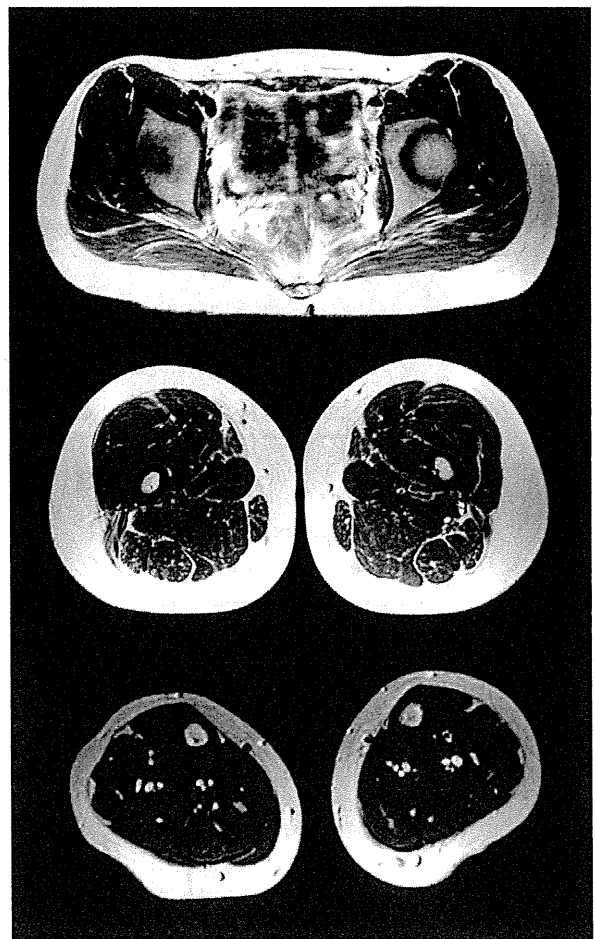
Muscle MRI, T2WI, axial. It shows high intensity in gluteus maximus and biceps femoris muscles.
